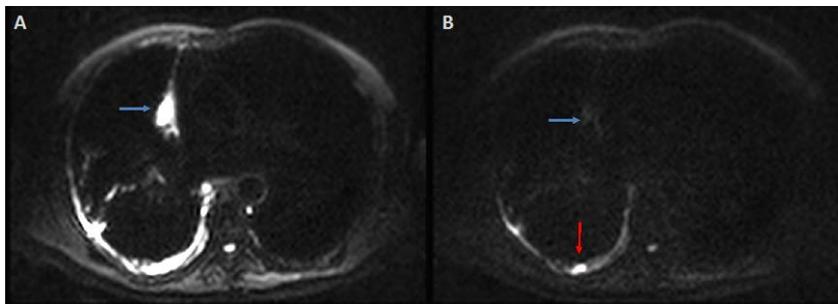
DWI images of (A.) b at 100 mm²/s and (B.) b at 800 mm²/s of a 69-year-old male who has malignant pleural mesothelioma. The mesothelioma tumour (red arrow) is more hyperintense than the pleural effusion (blue arrow) on the high-b-value DWI image.
